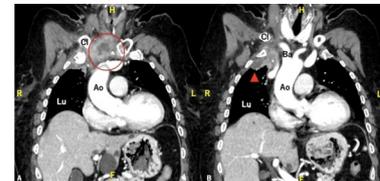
CT re-examination (A, B) on the fifth day showed an enlarged sternoclavicular joint abscess (circle) and extension into the mediastinum and extrapleural spaces (arrowhead). Ao, aorta; Ba, brachiocephalic artery; Cl, clavicle; F, foot; H, head; Lu, lung; L, left; R, right.
